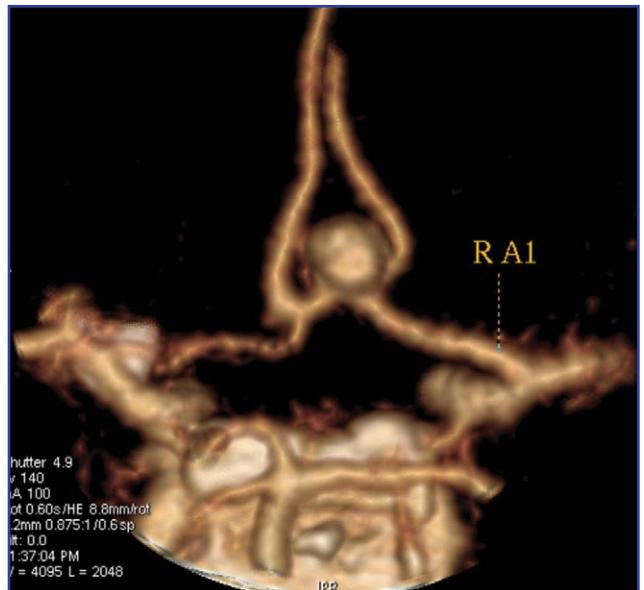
CTA image showing aneurysm.
